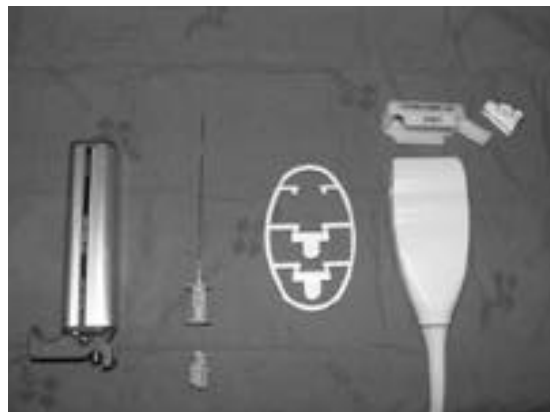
Biopsy needle, automated gun and attachment for ultrasound.
